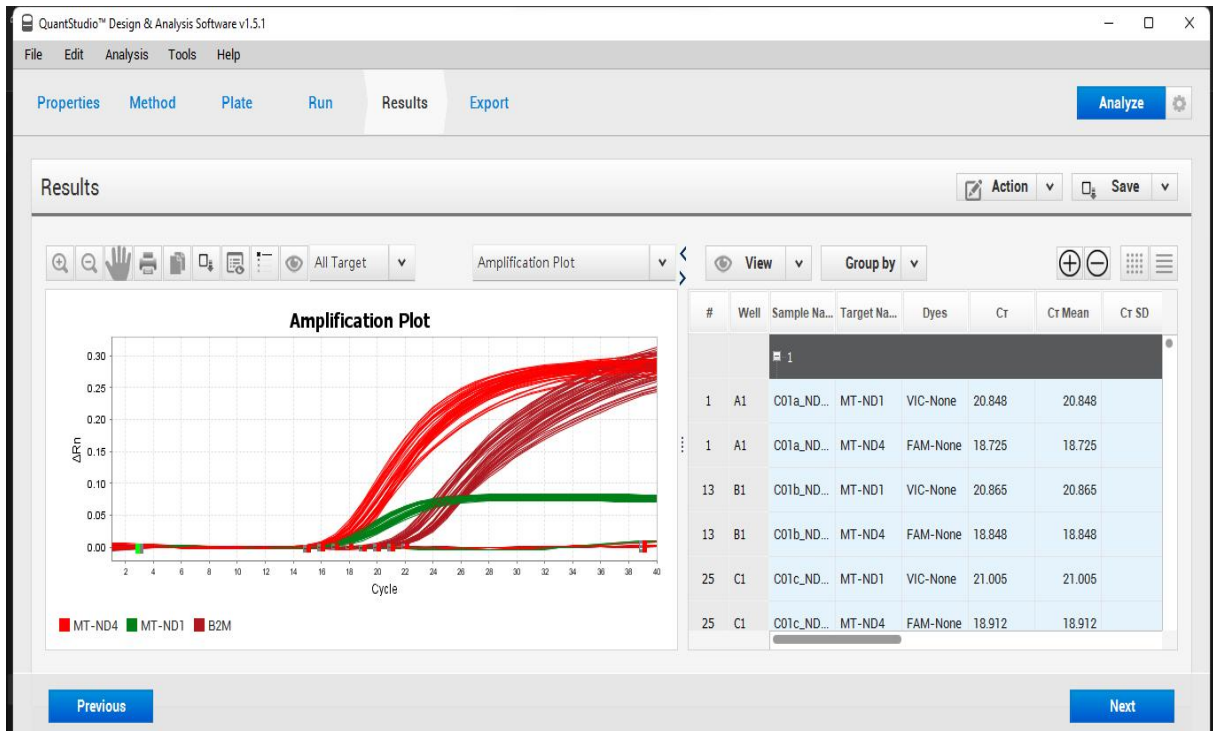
Pictorial representation of amplification plot of gene targets, showing dyes, and CT values in Quant studio 5 machine.
